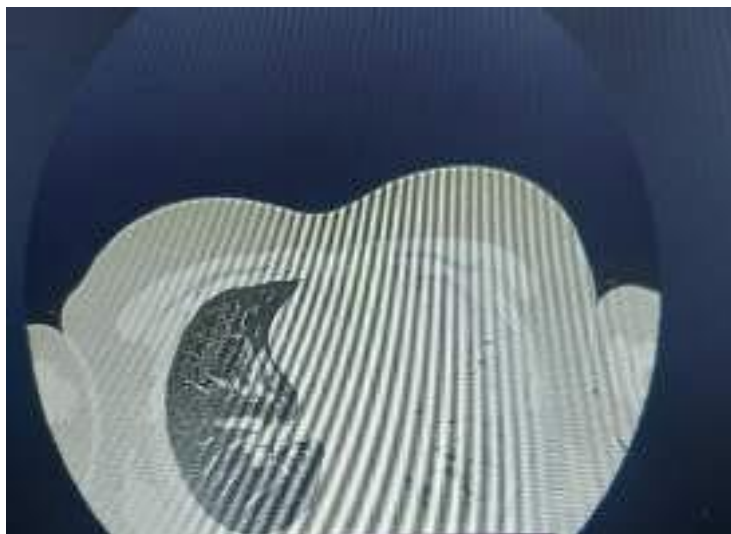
Computed Tomography Scan - Larger zone of parenchymal consolidation in the lower left lobe with a positive air bronchogram, pleural effusion on the same side and small pericardial effusion.
